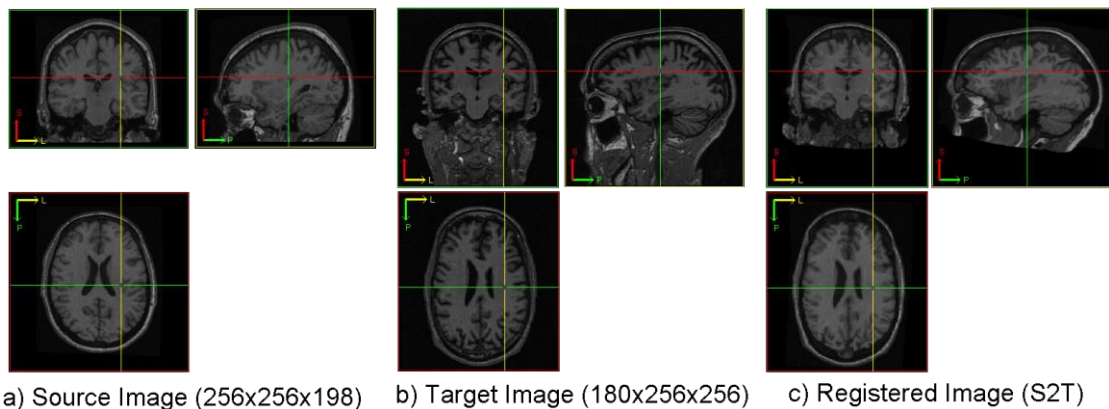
Registration of source images (a) with target images (b) to get the registered images (c) with sagittal, coronal and axial views in MRI.
